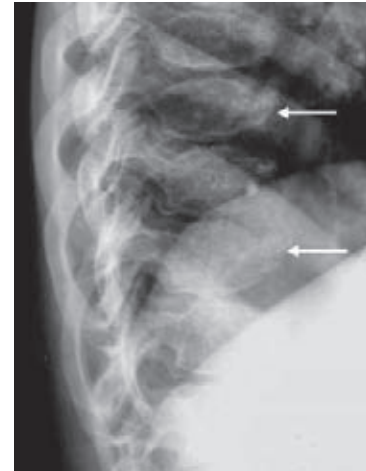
Morquio's syndrome. Lateral radiograph of lower thoracic spine demonstrates decreased height of the vertebral bodies (platyspondyly). Note the central anterior bony protrusion or beaking of the vertebral bodies (arrows)
